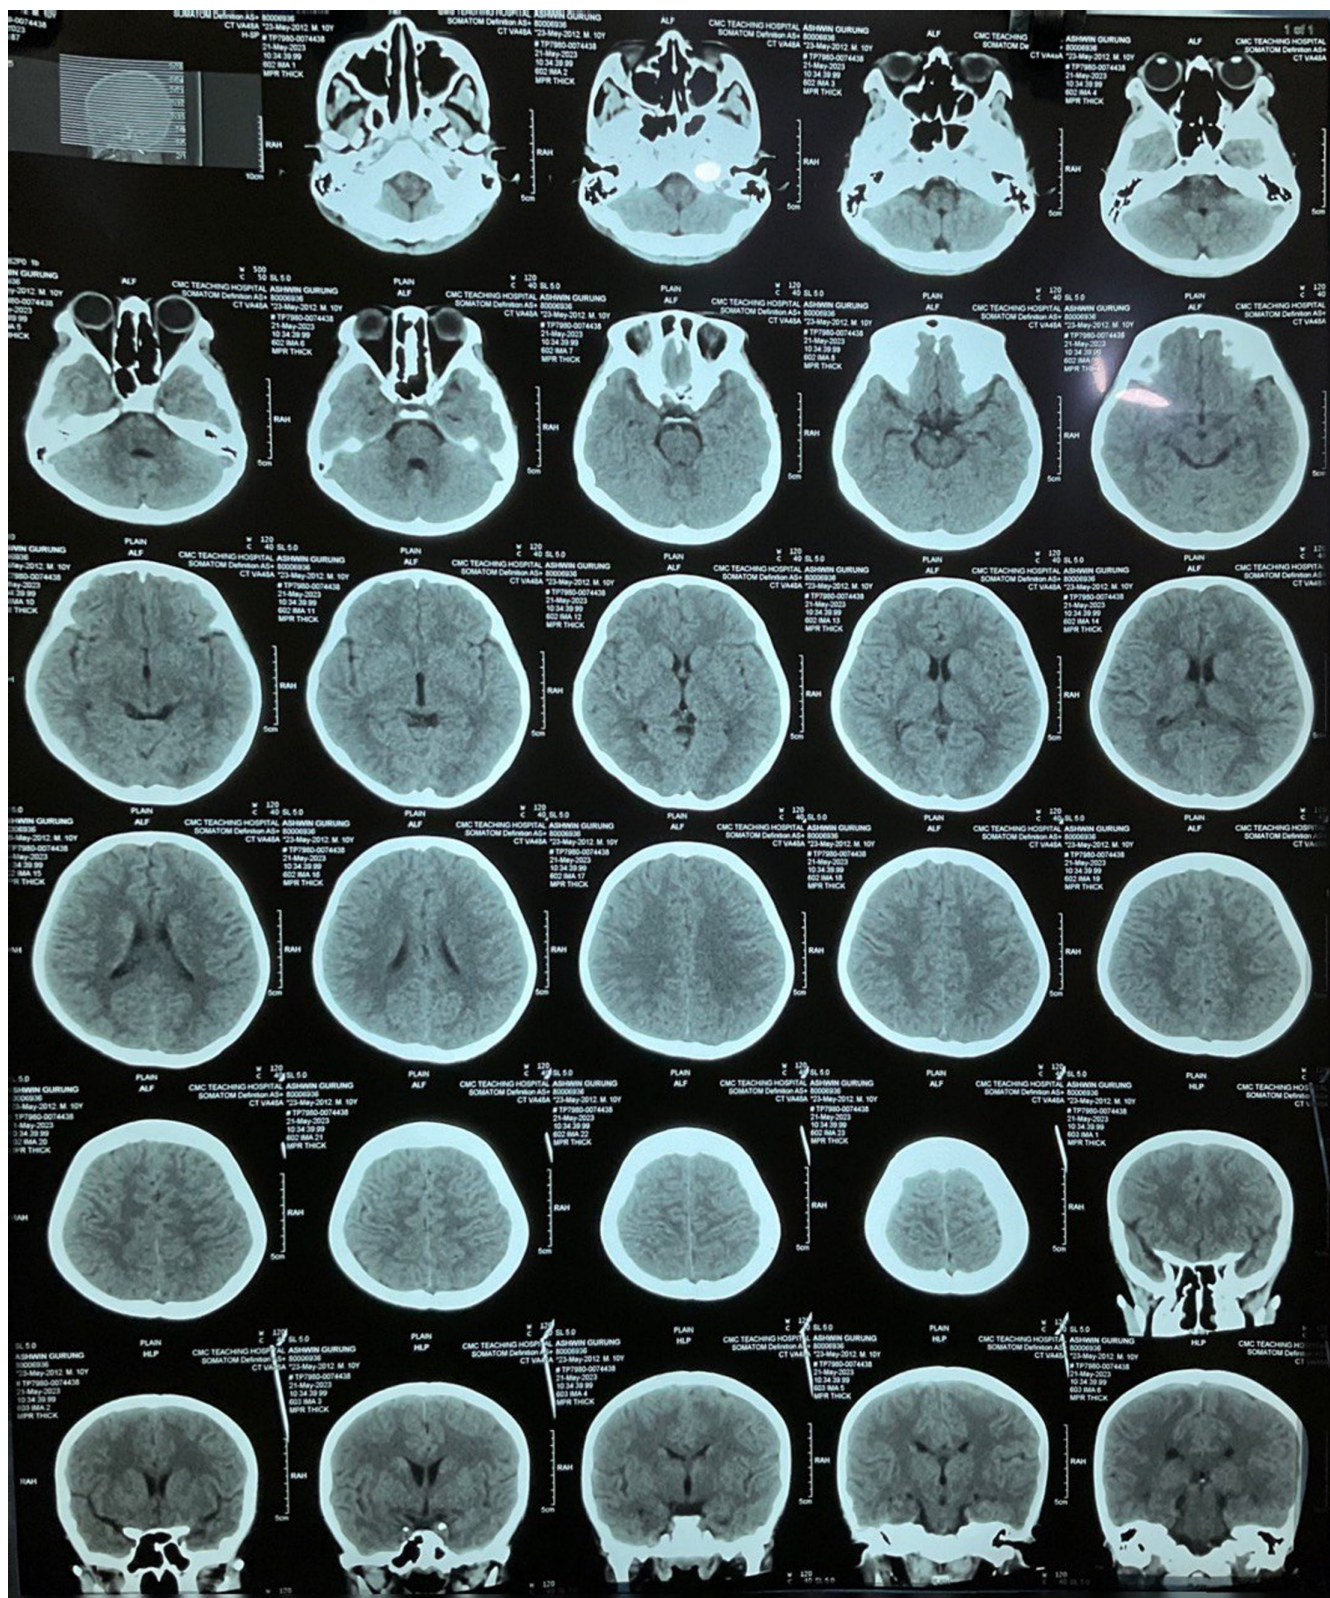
Computed tomography of head shows subtle hypodensities in the bilateral occipital lobes (left > right) suggestive of posterior reversible encephalopathy syndrome.
